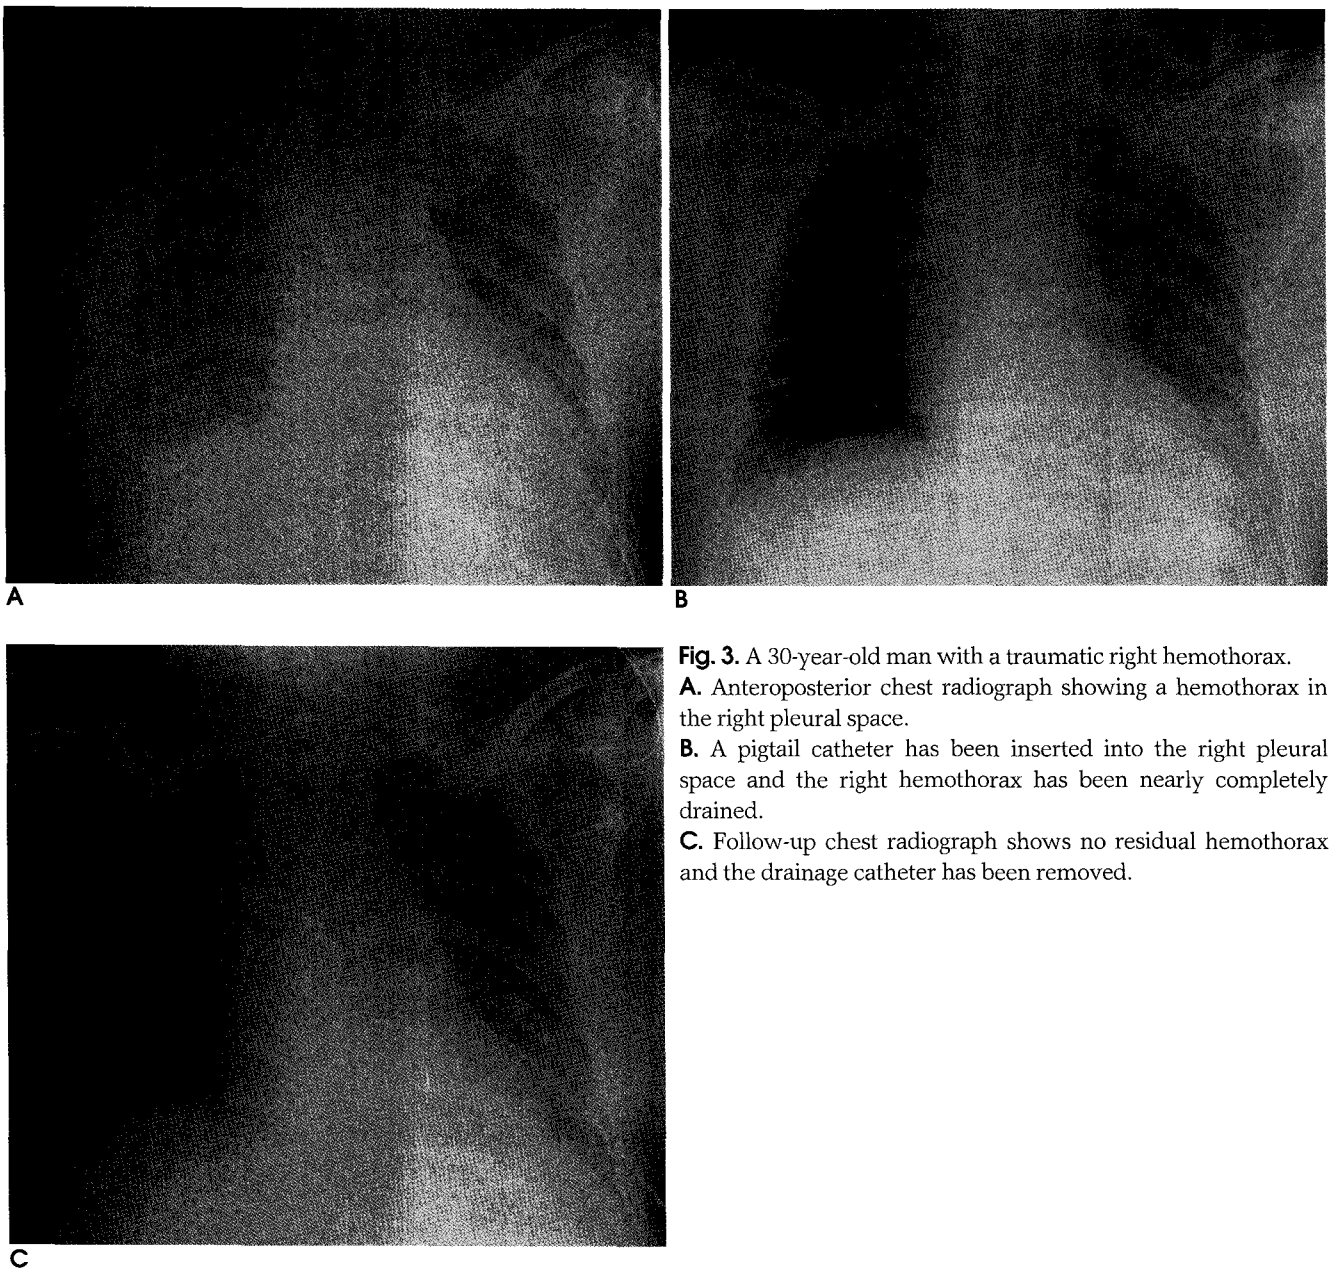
A 30-year-old man with a traumatic right hemothorax. A. Anteroposterior chest radiograph showing a hemothorax in the right pleural space. B. A pigtail catheter has been inserted into the right pleural space and the right hemothorax has been nearly completely drained. C. Follow-up chest radiograph shows no residual hemothorax and the drainage catheter has been removed.
